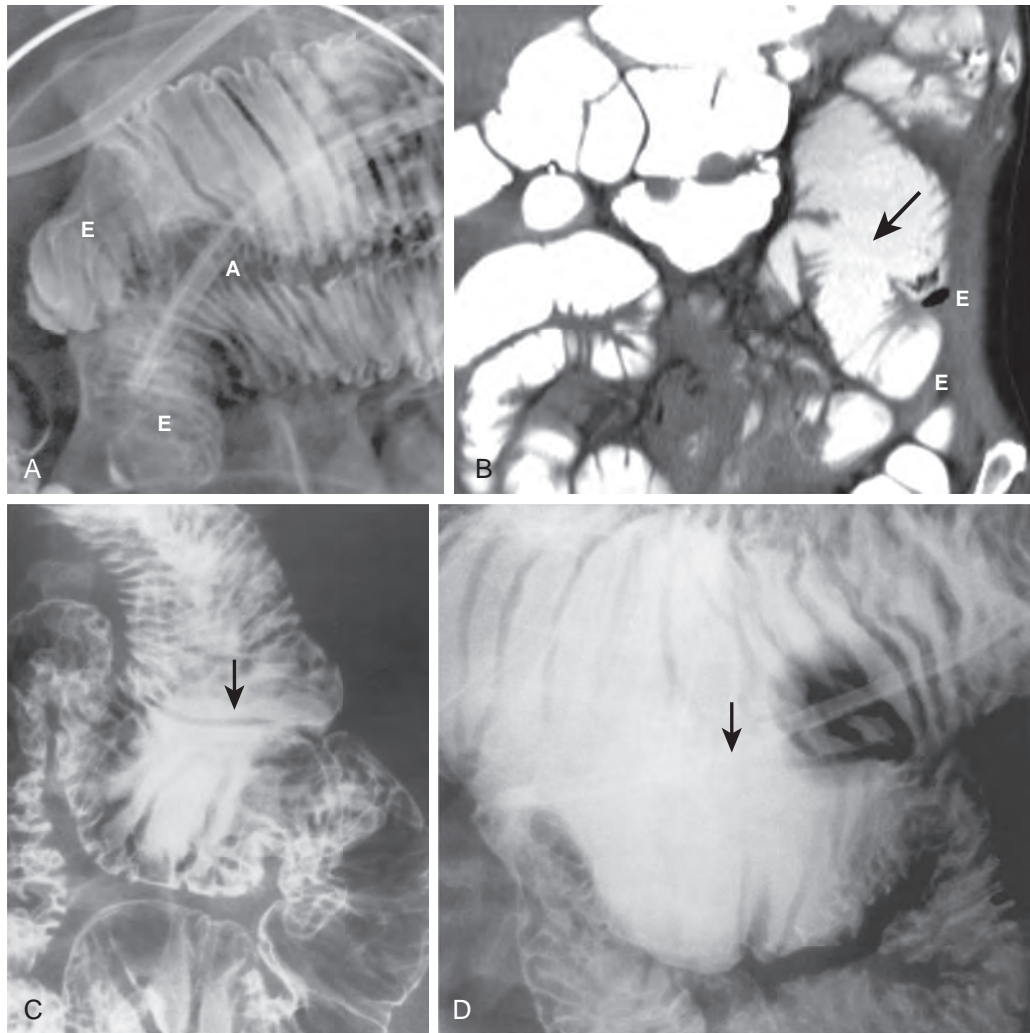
Intestinal anastomoses. A. Functional end-to-end jejunal anastomosis, created by an anatomic side-to-side technique, is evident on enteroclysis with characteristic short oversewn ends (E) in close proximity to a broad anastomotic lumen (A) traversed by the catheter. B. Functional end-to-end anastomosis (arrow) demonstrated on a coronal CT enteroclysis image with similar anatomic features. E indicates oversewn ends of the proximal and distal loops. C. End-to-side anastomosis (arrow). D. Side-to-side anastomosis (arrow). (From Lappas JC, Maglinte DD: Imaging of the postsurgical small bowel. *Radiol Clin North Am* 41:305–326, 2003.)
